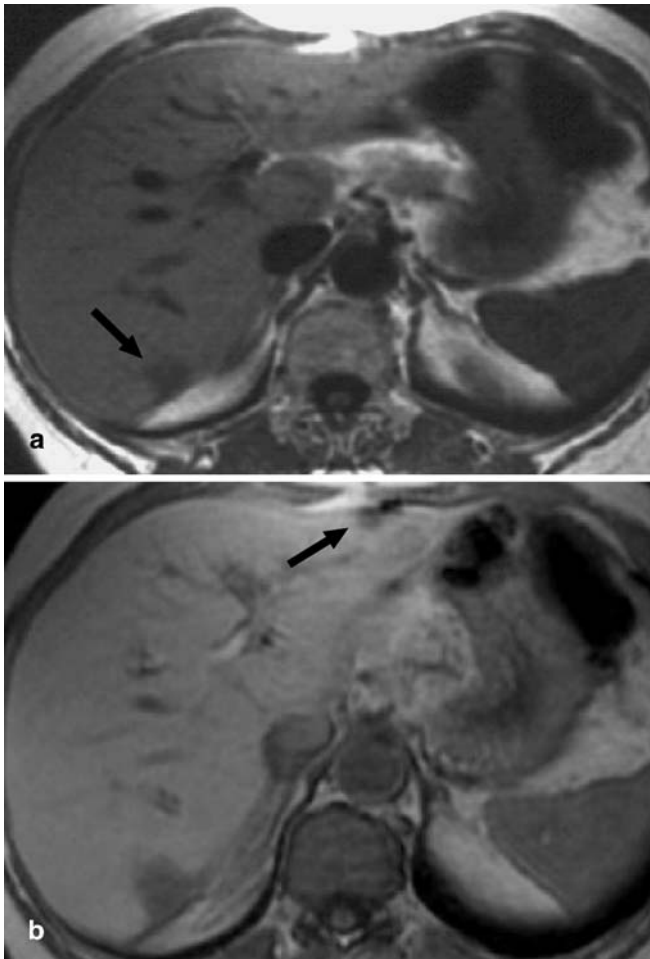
a Unenhanced T1-weighted MR image shows solitary metastasis in segment VII (*arrow*). b After injection of mangafodipir trisodium (MnDPDP), lesion conspicuity is increased, and a second metastasis, undetected by baseline MR examination, is observed in the anterior subcapsular aspect of segment III (*arrow*)
